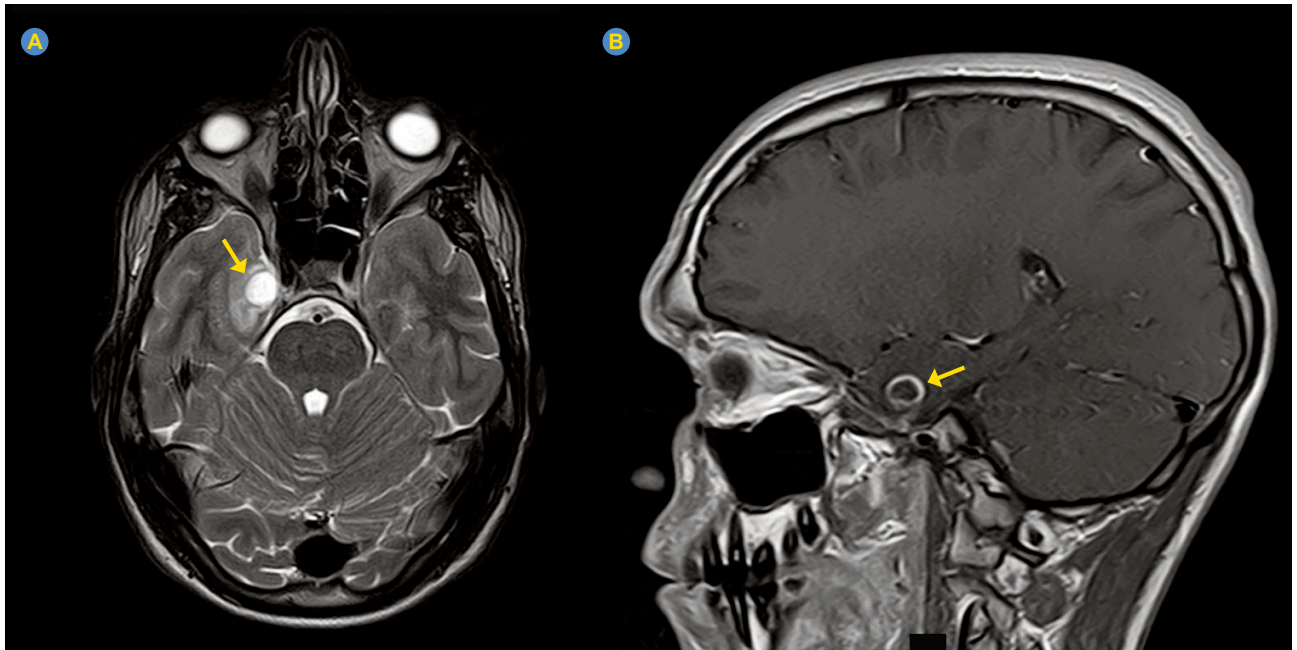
MRI image: axial (A) and sagittal (B) views showing the tumor on the right temporal lobe (arrows)
